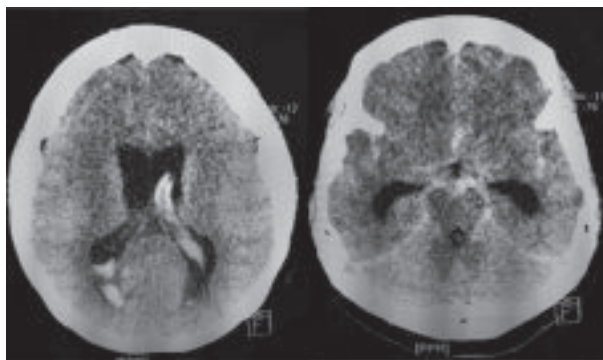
CT scan of brain shows bilateral ACA.
